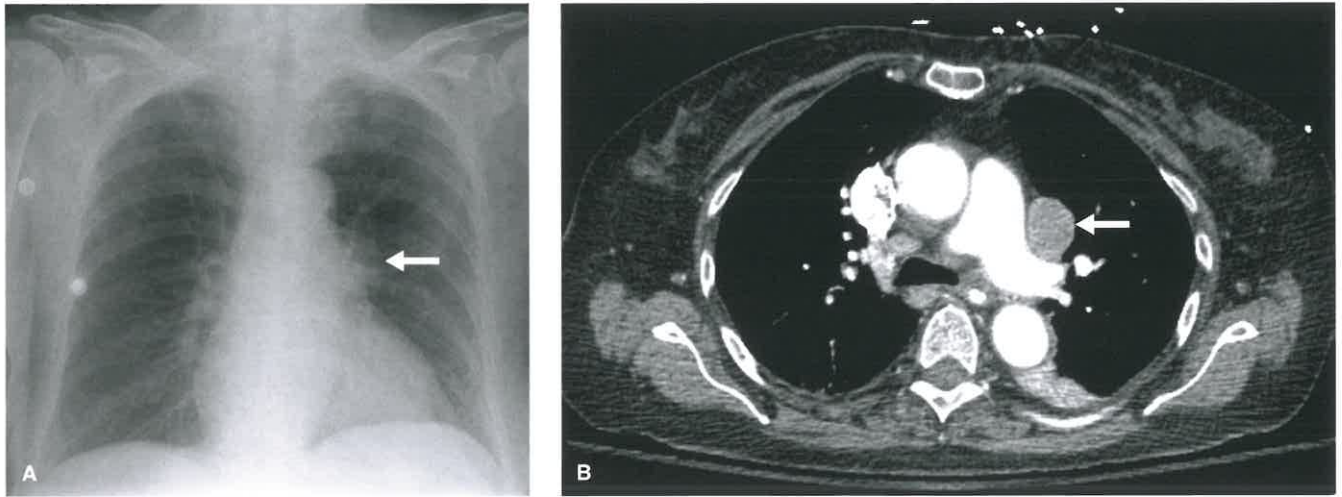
Hilar Nodal Metastases From Ovarian Carcinoma. A: Frontal chest radiograph in an 83-year-old woman with ovarian carcinoma shows a left hilar mass (arrow). B: Axial contrast-enhanced CT shows an enlarged left hilar lymph node (arrow) reflecting metastatic disease.
